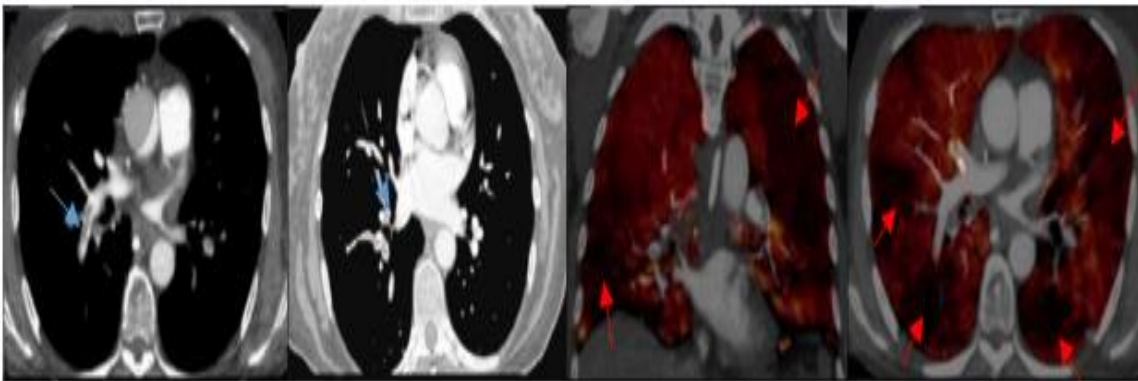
Female 55 years old presented to emergency room with severe chest pain dyspnea, sweating, tachycardia patient was suspected for pulmonary embolism after exclusion of other causes CT pulmonary angiography showed insufficient contrast in branches of left pulmonary artery (blue arrow). Iodine mapping showed bilateral filling defect (red arrow).
